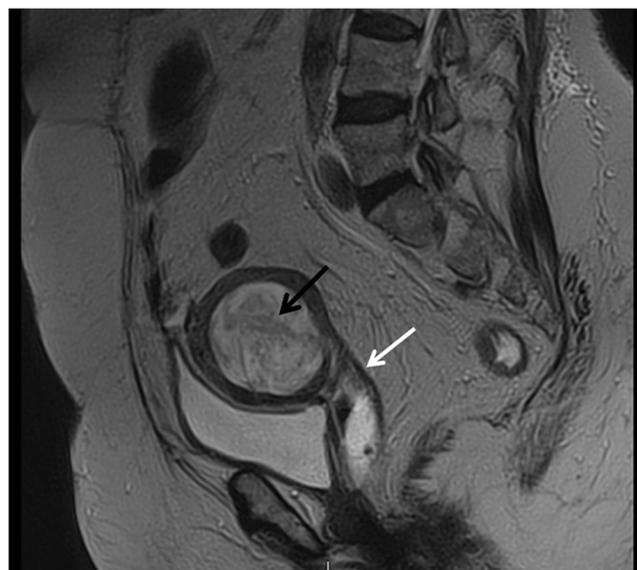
Magnetic resonance imaging (sagittal section). Mass in uterin cavity (black arrow) with neovagina infiltration (white arrow).
